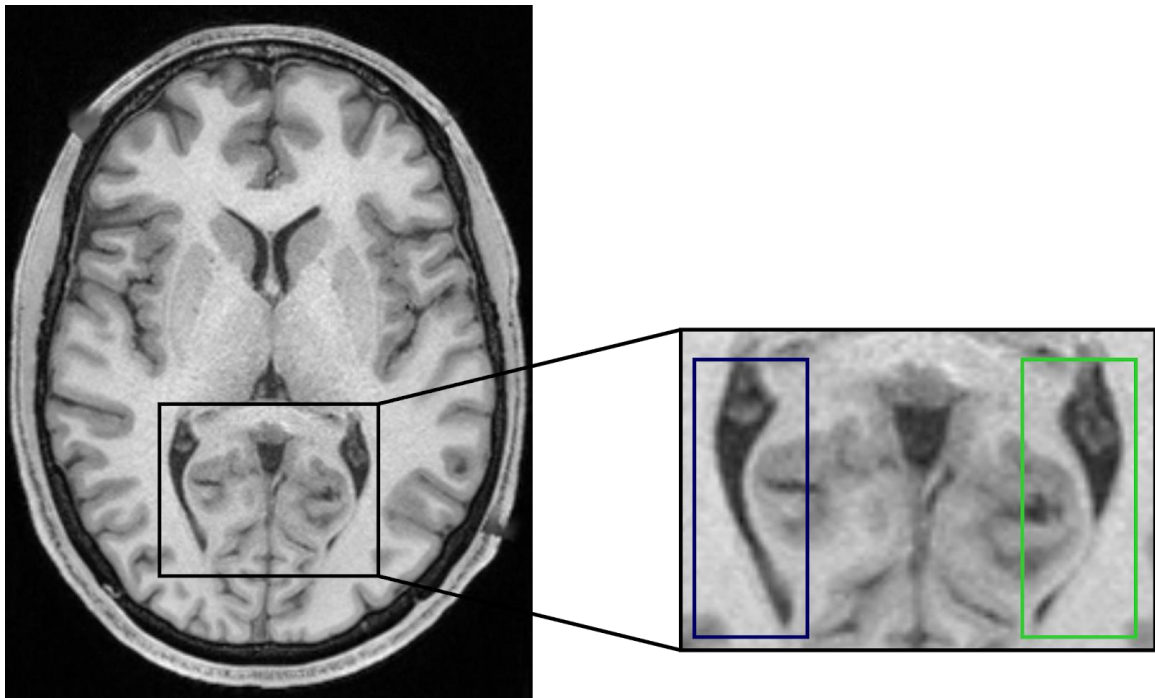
MRI Visualization of Posterior Horn Continuity. Axial MRI exhibiting a case Continuous (C) (dark blue box) and Discontinuous (D) PH (green boxes).
